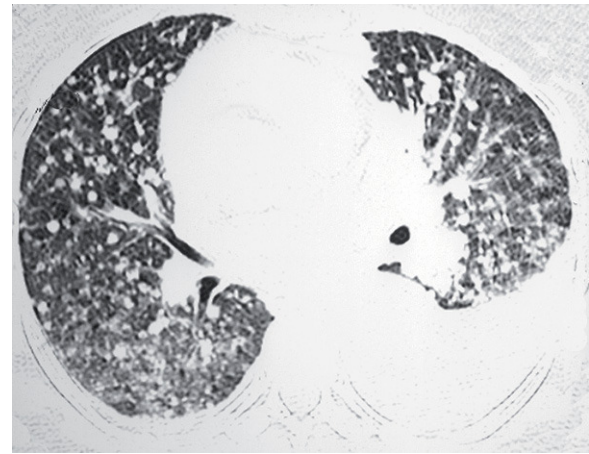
High-resolution CT image of the lower lung lobes, showing multiple small nodules that are poorly defined and are distributed randomly, as well as areas of ground glass attenuation in both lungs. Left pleural effusion can also be appreciated.
